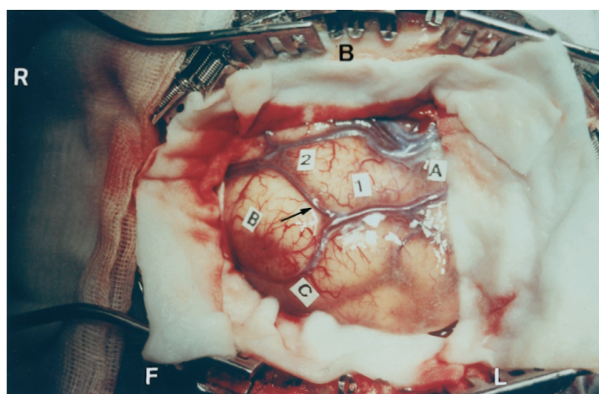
Intraoperative view before surgical resection. Motor areas were mapped using direct cortical stimulation. Medially to laterally, the motor arm site (2), the motor hand site (1), and the motor finger sites (A) are indicated; the arteriovenous malformation (AVM) boundaries are also delineated (B and C). As demonstrated by preoperative functional MRI, we found a sulcus (arrow) and a gyrus without motor response between the functional areas and the AVM during surgery; the “precentral” gyrus was defined using anatomical but not functional criteria. F = forward; B = backward; L = left; R = right.
